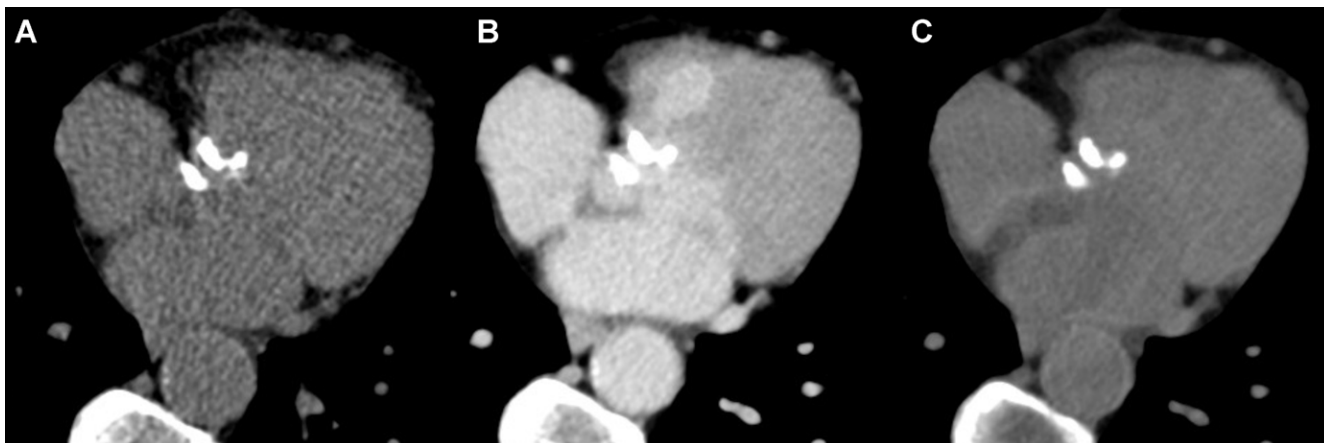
Representative CT images with aortic valve calcifications. Axial CT images in a 75-year-old female patient with severe aortic stenosis show (A) true noncontrast (at 70 keV without quantum iterative reconstruction [QIR]), (B) late enhancement (at 55 keV with QIR 3), and (C) virtual noncontrast (at 80 keV with QIR 3). Volume CT dose index of the true noncontrast and late enhancement scans were 1.9 mGy and 4.6 mGy, respectively. The aortic valve calcium scores were 2053 on true noncontrast images and 2051 on virtual noncontrast images (at 80 keV with QIR 4).
